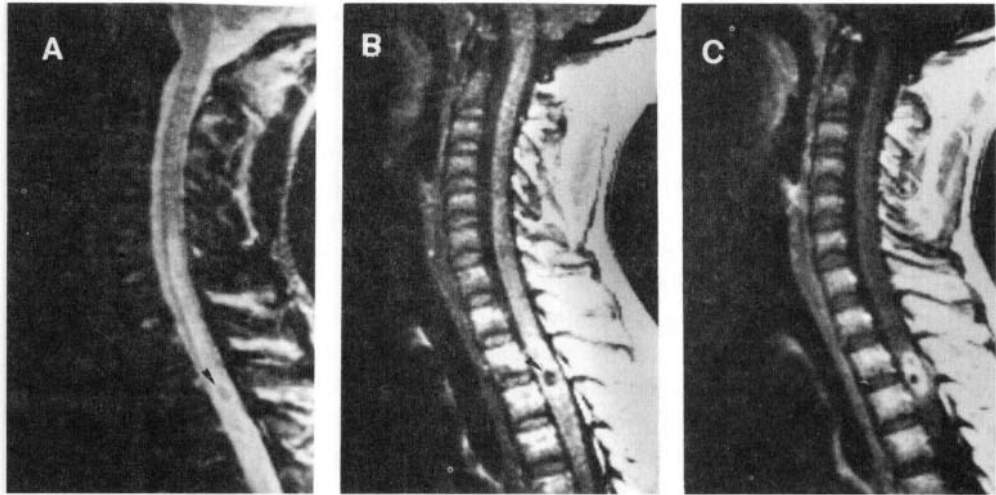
Intramedullary cysticercosis. Sagittal T2-weighted image (a) of the cervicothoracic region shows a hypointense area (arrowhead) with surrounding hyperintensity in the cord. On T1-weighted image (b) the lesion appears hypointense with a hyperintense nodule suggestive of scolex (arrowhead). Postcontrast T1-weighted image (c) shows thick peripheral enhancement.
